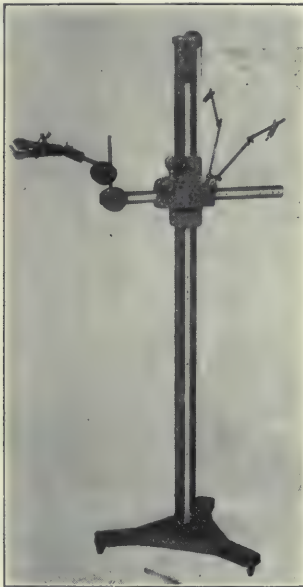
Author's X-Ray Tube Stand.
